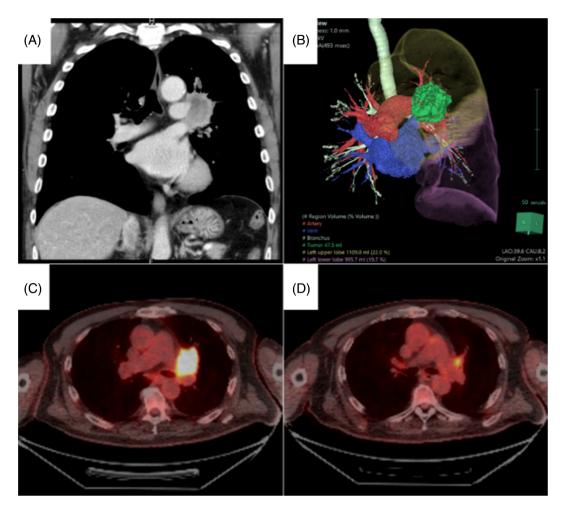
Serial examinations before treatment by (A) chest computed tomography (CT). (B) The tumour shows an invasion to the left pulmonary artery and bronchus in the CT reconstruction image. (C, D) The tumour and hilar lymph node exhibit a high standard uptake value (SUV) in the PET/CT scan; the clinical staging was cT4N1M0, stage IIIA.
